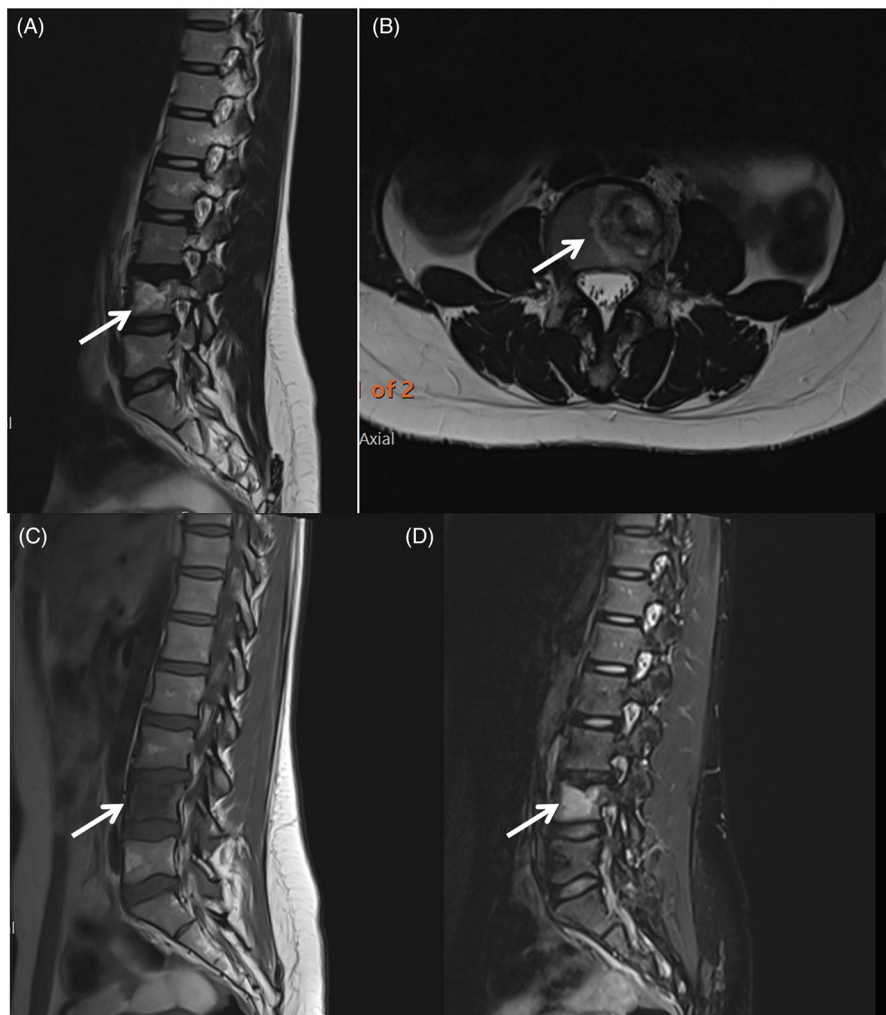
MRI at diagnosis. (A) This is a sagittal T2W MRI image showing the L4 hyperintense lesion (arrow). (B) This is an axial T2W MRI image at the level of L4 demonstrating the lesion and the surrounding bone oedema (arrow). (C) This is a sagittal T1W MRI image showing the L4 lesion with intermediate intensity (arrow). (D) This is a sagittal STIR MRI image showing the L4 hyperintense lesion (arrow).
